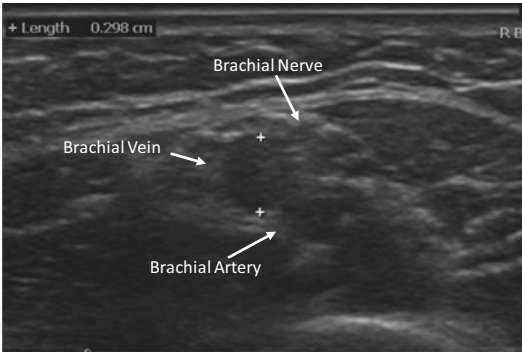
Ultrasound view of the brachial nerve
